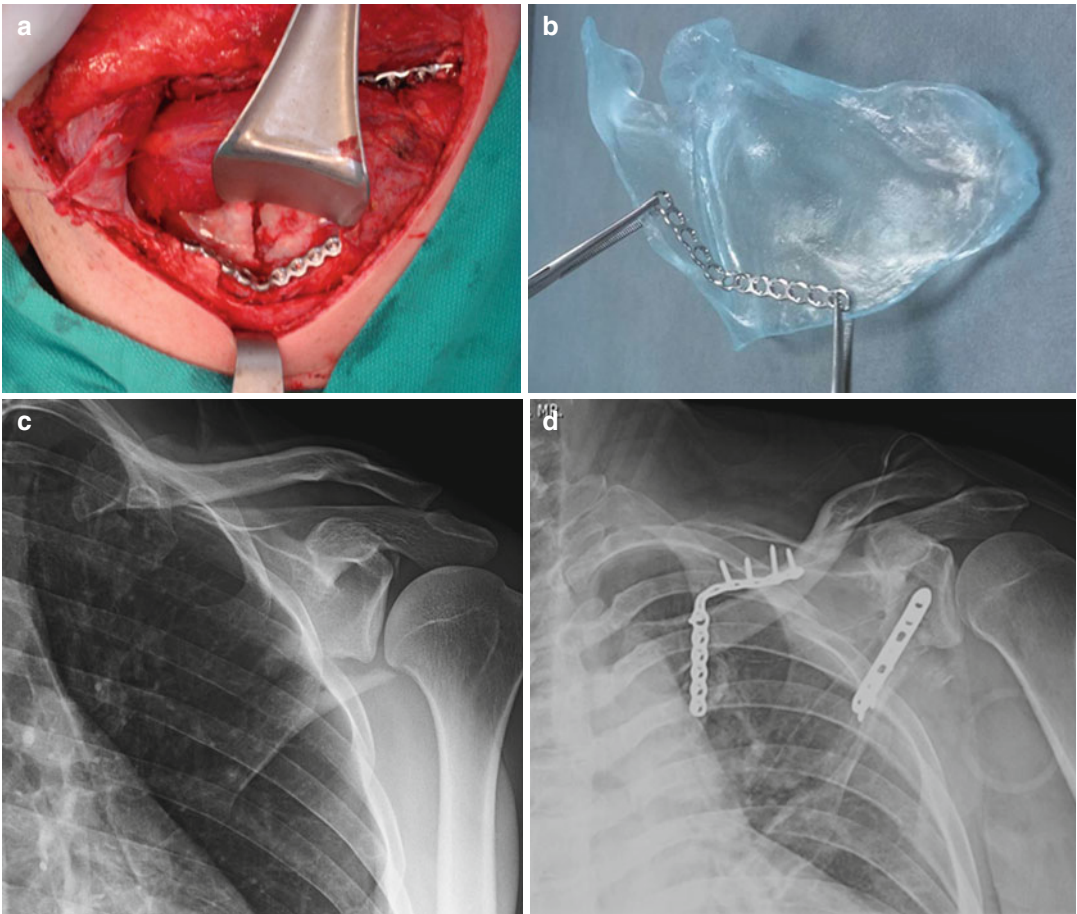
(a) Intraoperative image of Judet approach with medial and lateral border plating. (b) Though a Judet incision was made, intermuscular windows were developed to access the borders for reduction and fixation. The lateral border is accessed through the interval between teres minor and infraspinatus. (c) An AP injury x-ray
